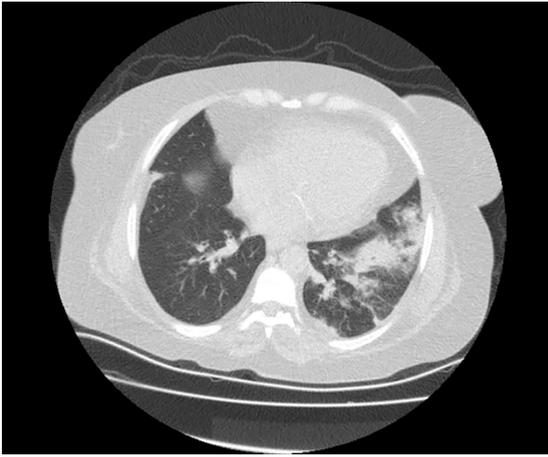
Computed tomography scan of the chest, which showed consolidation areas with air bronchogram in the left lung lower lobe, and pneumonic infiltration. Coronavirus disease 2019 was not eliminated.
